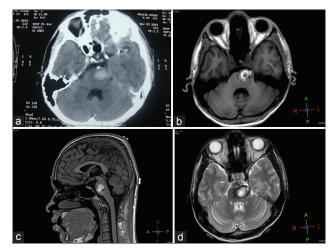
(a) Plain computed tomographic scan showing hyperdense lesion in left half of pons. (b) Magnetic resonance imaging (MRI) T1-weighted axial image showing hyperintense lesion. (c) MRI T1-weighted sagittal images showing hyperintense lesion. (d) MRI T2-weighted image showing hyperintense lesion with hemosiderin ring
